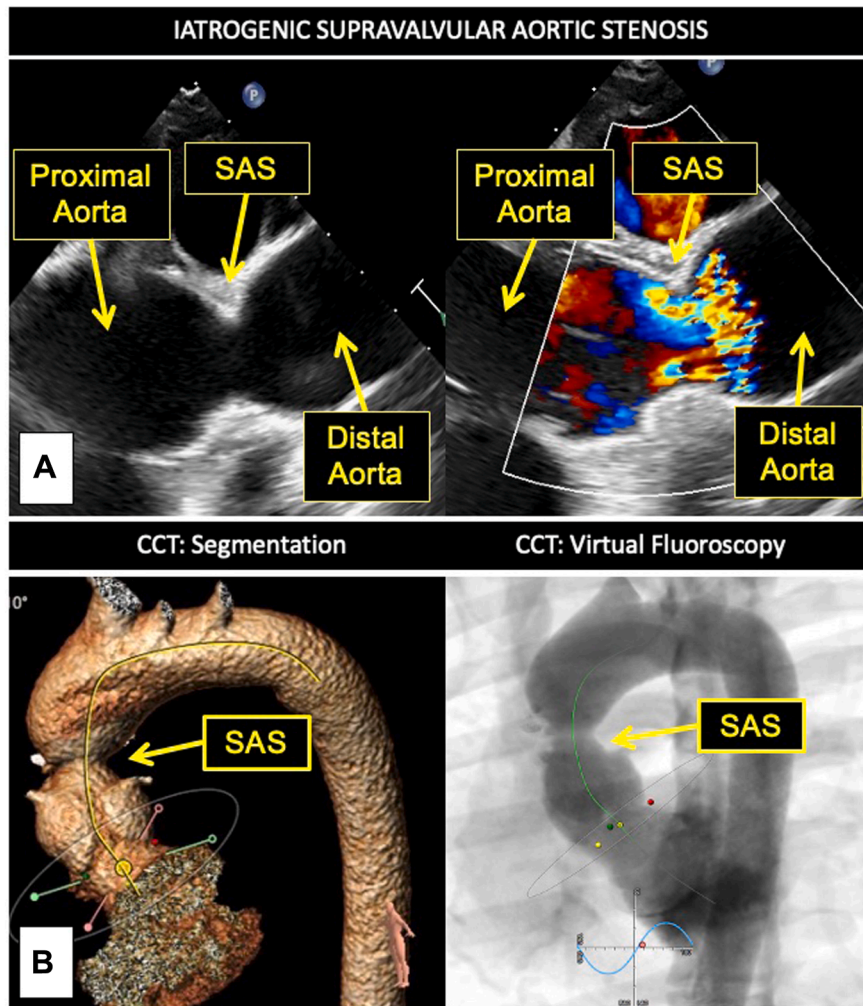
(A) Two-dimensional TEE (*top*), midesophageal zoomed long-axis systolic view centered on the ascending aorta without (*left*) and with (*right*) color flow Doppler of the iatrogenic SAS, demonstrates the focal narrowing with the turbulent flow in the ascending aorta. (B) CCT (*bottom*), three-dimensional volume-rendered reconstruction (*left*) and virtual fluoroscopy (*right*), sagittal display, demonstrates the iatrogenic SAS.
